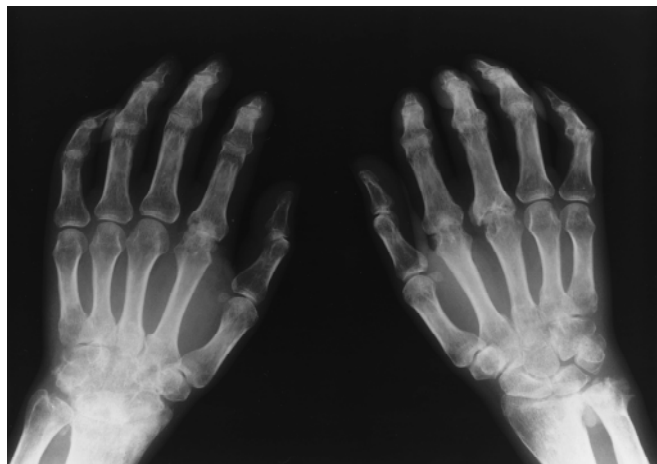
An anteroposterior hands and wrists radiograph showing bony erosion and destruction of the right second and third, and the left second metacarpophalangeal joints and the left carpal bones. In addition, bony resorption of all distal phalanges is seen
